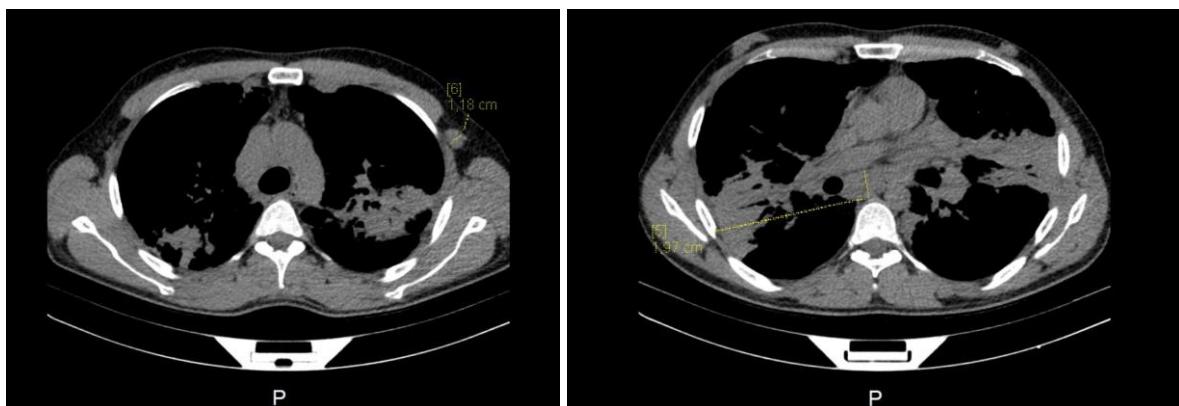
CT Axial non-contrast demonstrating bilateral consolidation, numerous military and micro-nodules and enlarged mediastinal lymph nodes.
